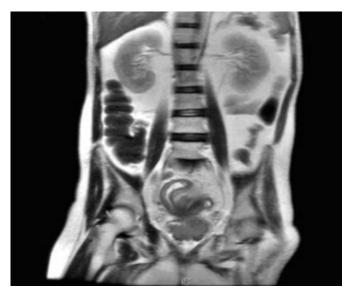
Coronal view of the MRI showing the same findings as in figure 6.
